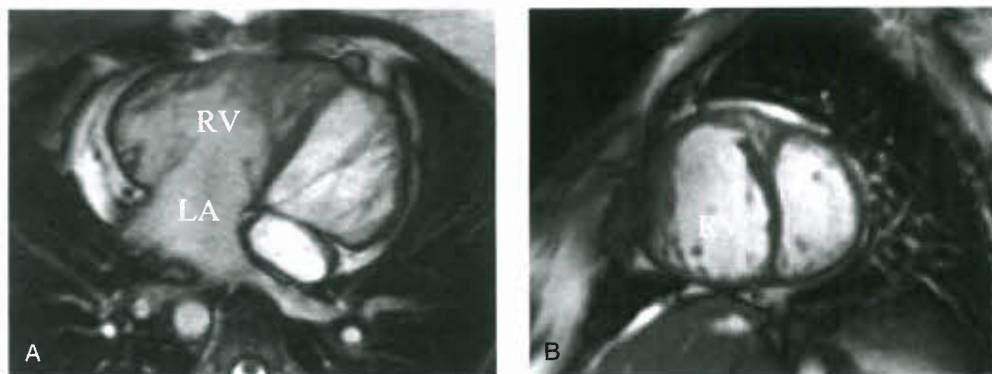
Cardiovascular magnetic resonance imaging of a 36-year-old patient with congenitally corrected transposition of the great arteries. A: Four-chamber view, note the left atrium to the enlarged right ventricle (RV) supporting systemic circulation. B: Sagittal two chamber view showing an enlarged systemic RV.
